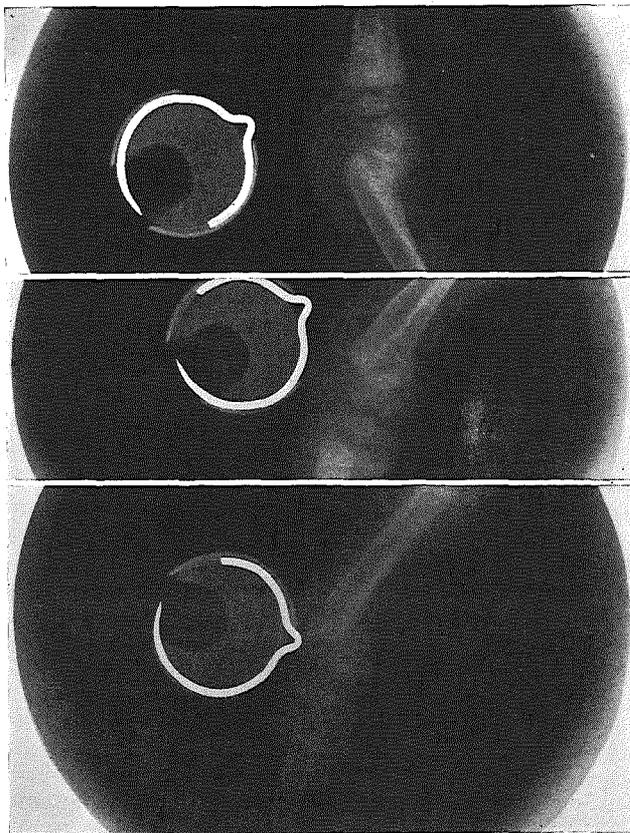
X-rays of the tarso-metatarsal joints of five-weeks-old chicks used in Olssen's radiographic method of assay of vitamin D. The upper X-ray is from a chick receiving natural vitamin D₃ from cod-liver oil, the middle X-ray from a chick receiving the same number of International Units of synthetic vitamin D₂ (calciferol), and the lower X-ray is from a chick receiving no vitamin D. Note in the top X-ray the greater calcification and the narrower tarso-metatarsal gap. (See also Fig. 184.)
